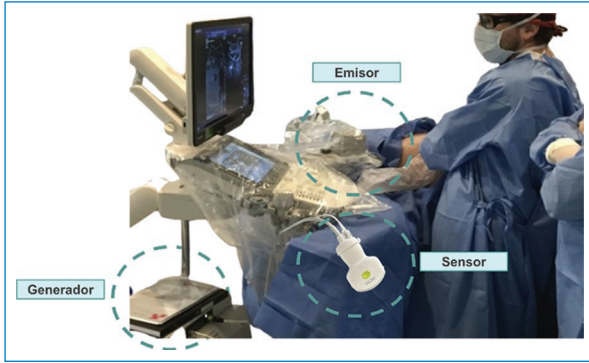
Representative image of the different components that make up the image fusion system attached to the ultrasound machine. The circles with dashed lines indicate its main elements: the electromagnetic wave generator, the emitter, and the sensor.
